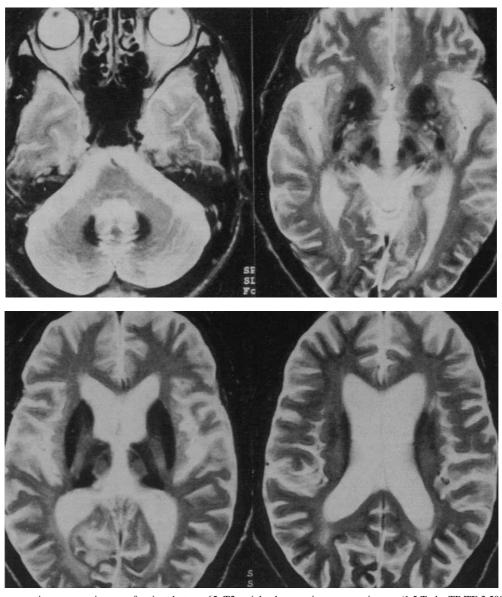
Brain magnetic resonance images of patient 1 at age 65. T2-weighted magnetic resonance images (1.5 Tesla, TR/TE 2,500/80) reveals an increased iron content in basal ganglia, thalamus, and dentate nucleus.
